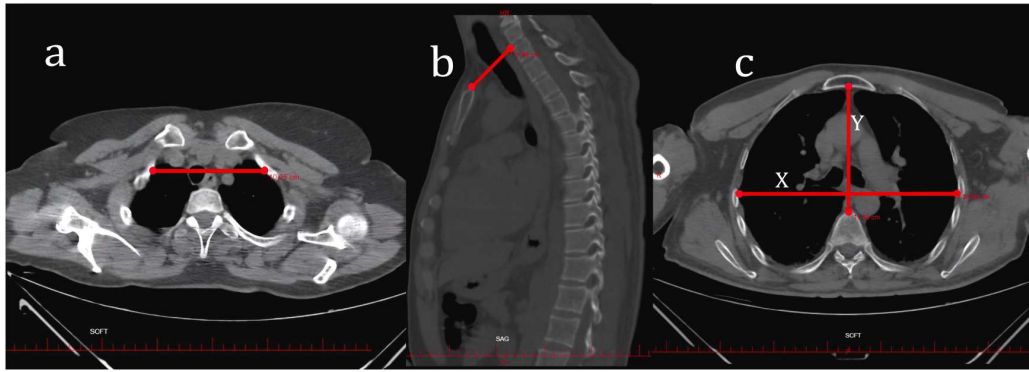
Representative axial Computed Tomography (CT) images demonstrating thoracic inlet measurements. (a) Transverse diameter (double-headed arrow) measured as the widest distance between the medial aspects of the first ribs. (b) Anteroposterior (AP) diameter (double-headed arrow) measured from the posterior aspect of the manubrium sterni to the anterior superior aspect of the T1 vertebral body. (c) Landmarks for the Haller index: the transverse diameter of the chest (X) divided by the shortest anteroposterior distance (Y) between the posterior surface of the sternum and the anterior surface of the vertebral body at the same axial level (typically the level of the xiphisternal joint or narrowest point).
